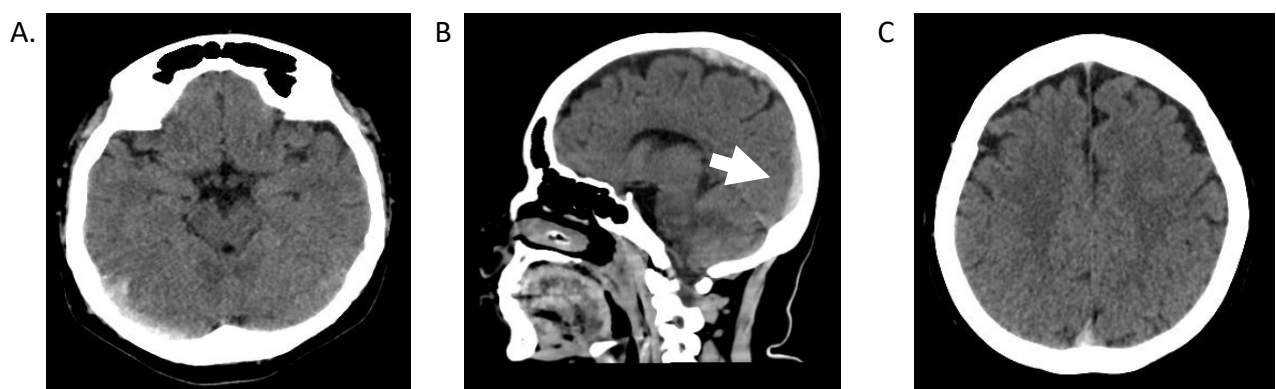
Non-contrast Head CT scan
